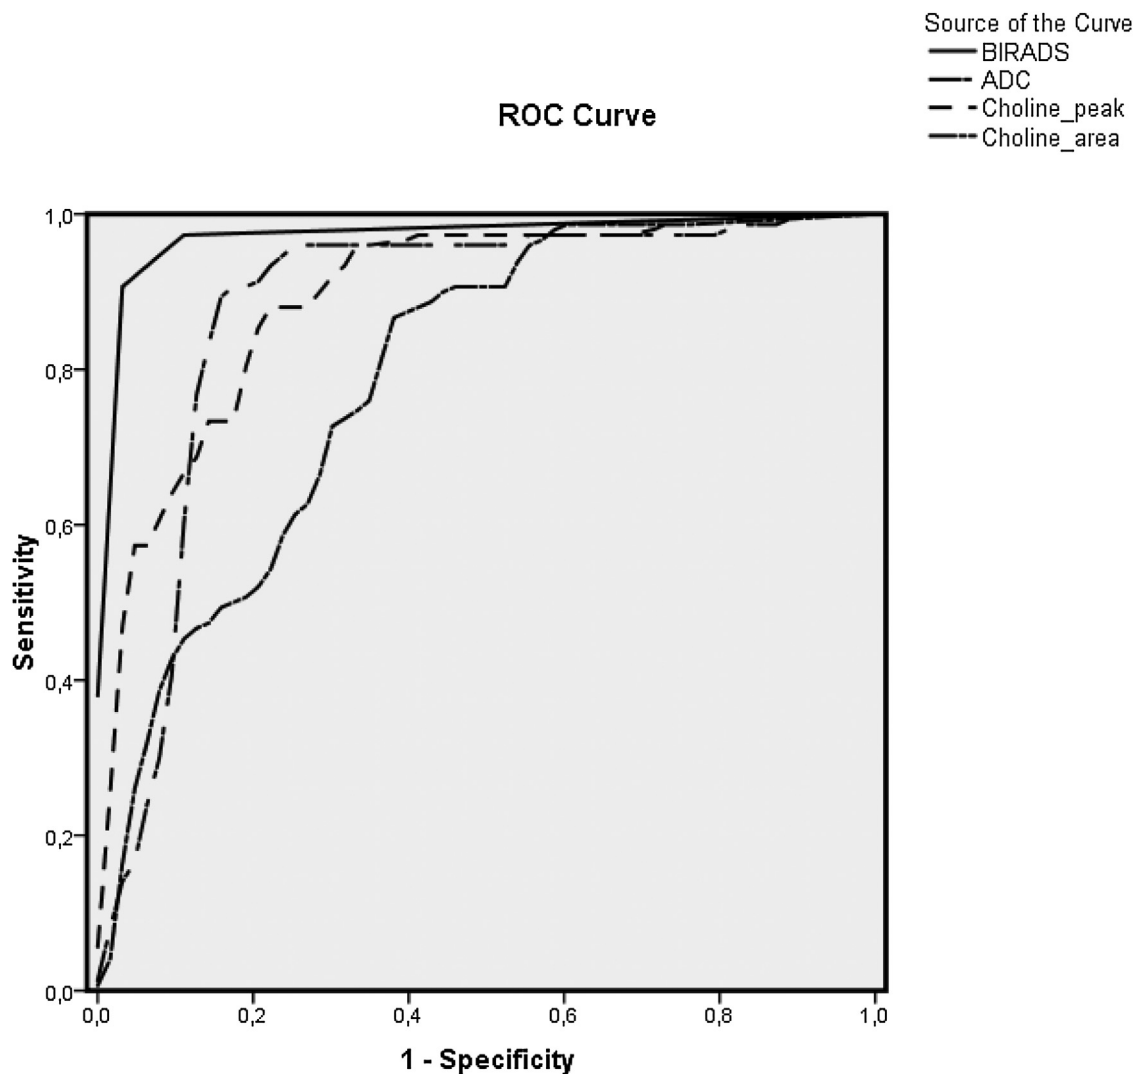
ROC analyses for BI-RADS category of DCEMRI (AUC = 0.978), ADC measurements in DWI (AUC = 0.878), 1H-MRS choline peak value (choline peak)(AUC = 0.895) and choline peak area under curve (choline area)(AUC = 0.792) measurements.
